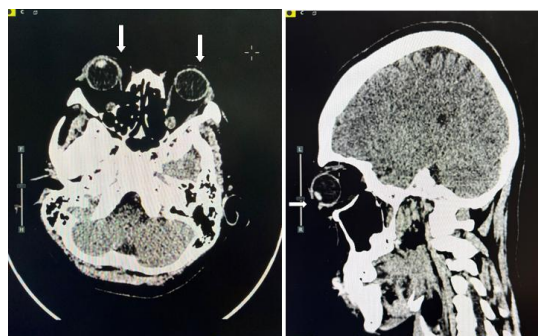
Computed tomography (CT) scan findings of the head and orbit. CT imaging revealed bilateral exophthalmos consistent with Graves' ophthalmopathy. Arrows demonstrate symmetric thickening of the extraocular muscles.
